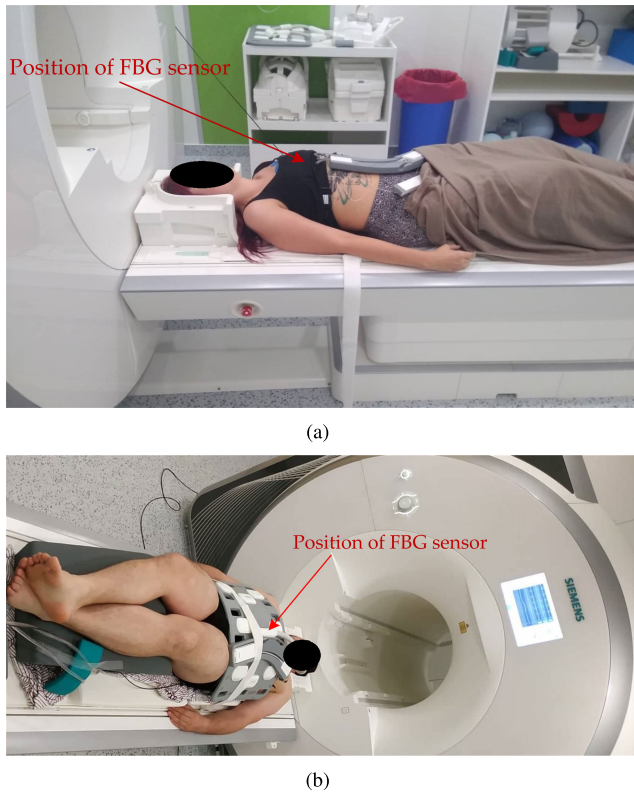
Photographs of patient instrumentation setting for triggered MRI scan: a) a female subject; b) a male subject.
